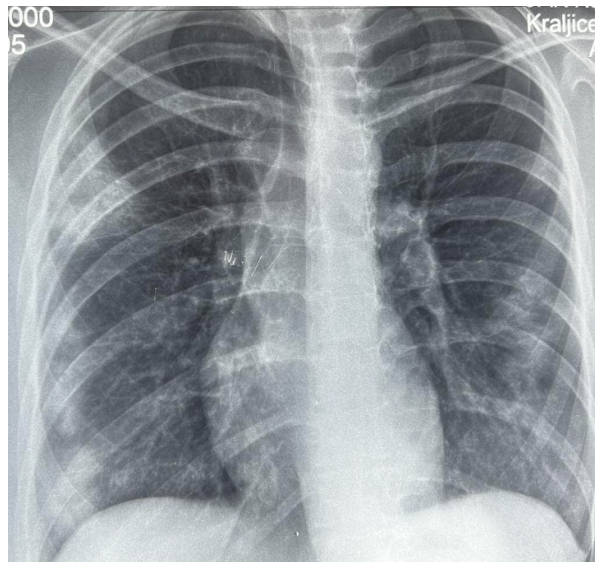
The second X-ray of the lungs
